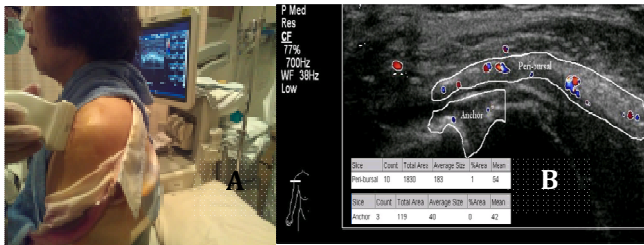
(A) Each Doppler sonography (with specific scanning mode and settings) was obtained by using the same setup for affected arm placement. (B) The images present two regions of interest (peri-bursal, and tendon adjacent to the repair site). By Doppler sonography, vascular particle number and area pixels count were obtained from Image J software.
